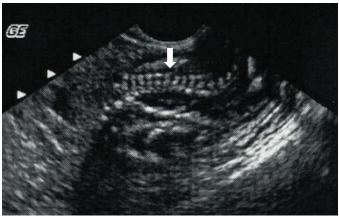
Grayscale endovaginal ultrasound (longitudinal plane) of the right pelvic mass demonstrating linear segmented hyperechoic structures within the mass suggestive of a fetal spine (white arrow).
